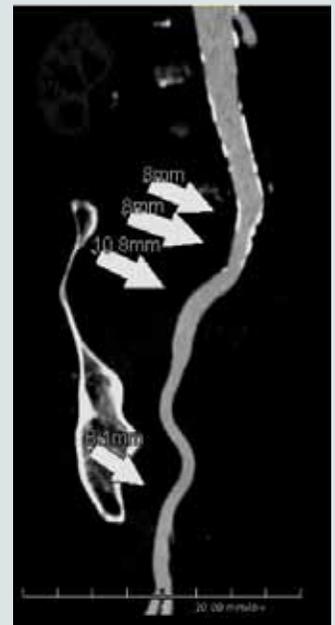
A CT angiography longitudinal view of the right iliac and femoral arteries shows an internal lumen diameter at least 8 mm throughout, adequate for the delivery system of either the 23-mm or 26-mm SAPIEN valve.
